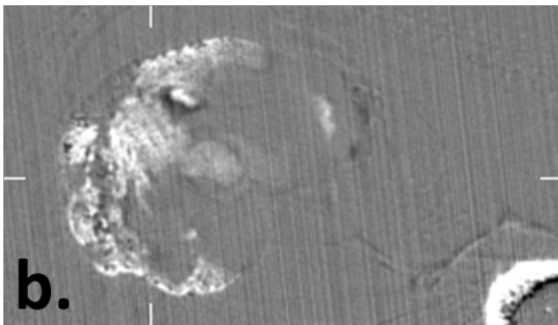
Low angle DEI computed tomography images in three orthogonal planes of the growth plate region in sample 1A. In figure a, the black arrow indicates the fracture, the white arrow indicates the growth plate.
